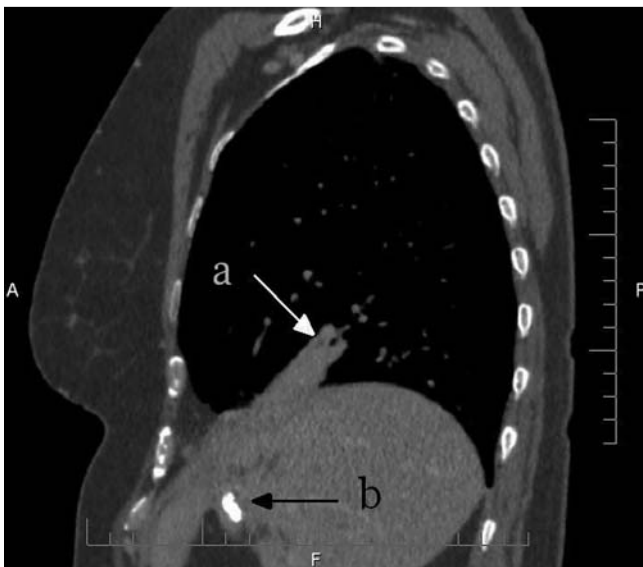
Abdominal and chest computed tomography (CT) image showing the presence of the fistula between the biliary system and the lower lobe of the right lung (arrow a) and the previously placed plastic biliary stents (arrow b).
